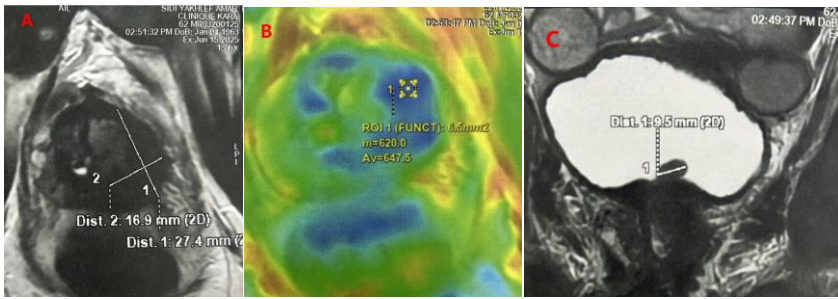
A: a large prostatic lesion range very strongly suspected of clinically significant neoplastic lesion (PI-RADS V2.1 5/5), of 27x17x35 mm interesting the left peripheral zone at the three stages, predominantly lateral, with peri-prostatic, of the neuro-vascular strip. B: MRI sequence in diffusion, area of interest ROI 1 suggestive of malignity (low ADC). C: prostatic lesion in continuity with a small nodular bud of the bladder floor of 09mm
